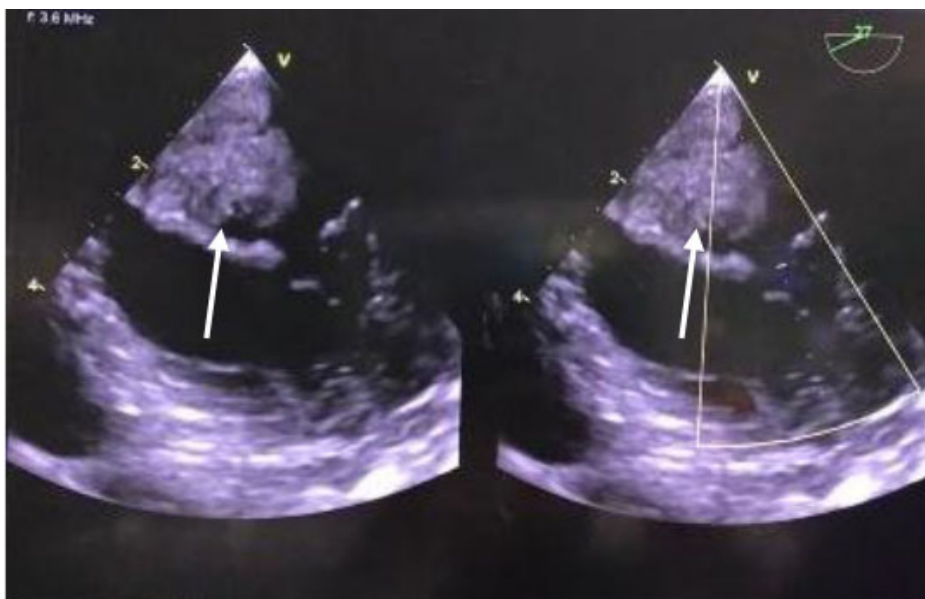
Trans Esophageal Echocardiography (TEE) show large vegetation on the mitral valve (white arrow).
